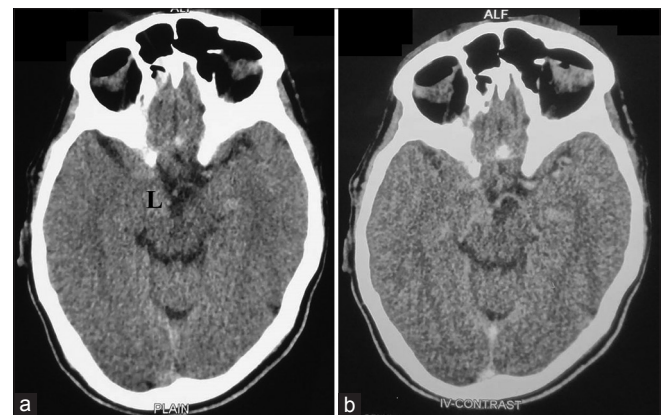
plain (a) and postcontrast (b) axial computed tomography images of the patient showing a mildly enhancing mass lesion (L) involving right medial temporal region and uncus
